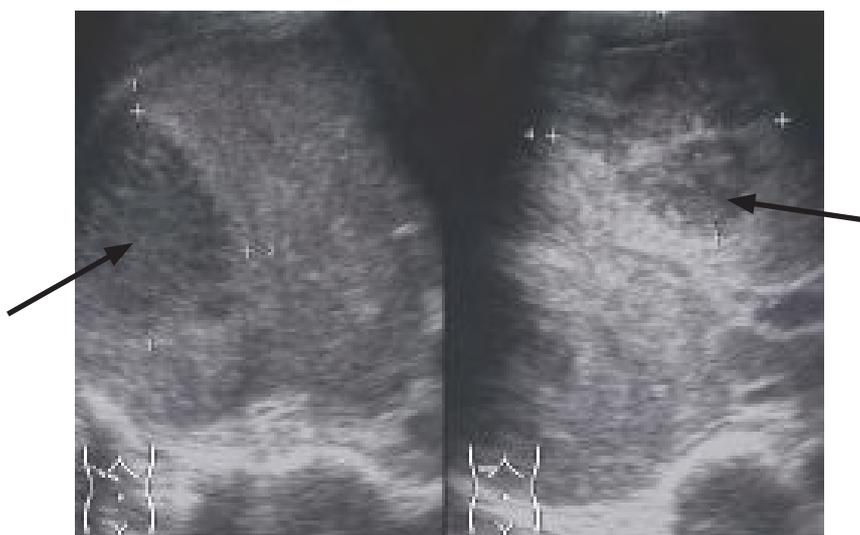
Ultrasound of liver showing the presence of multiple, well-defined, hypoechoic lesions (arrows) with cavity debris in the right hepatic lobe
